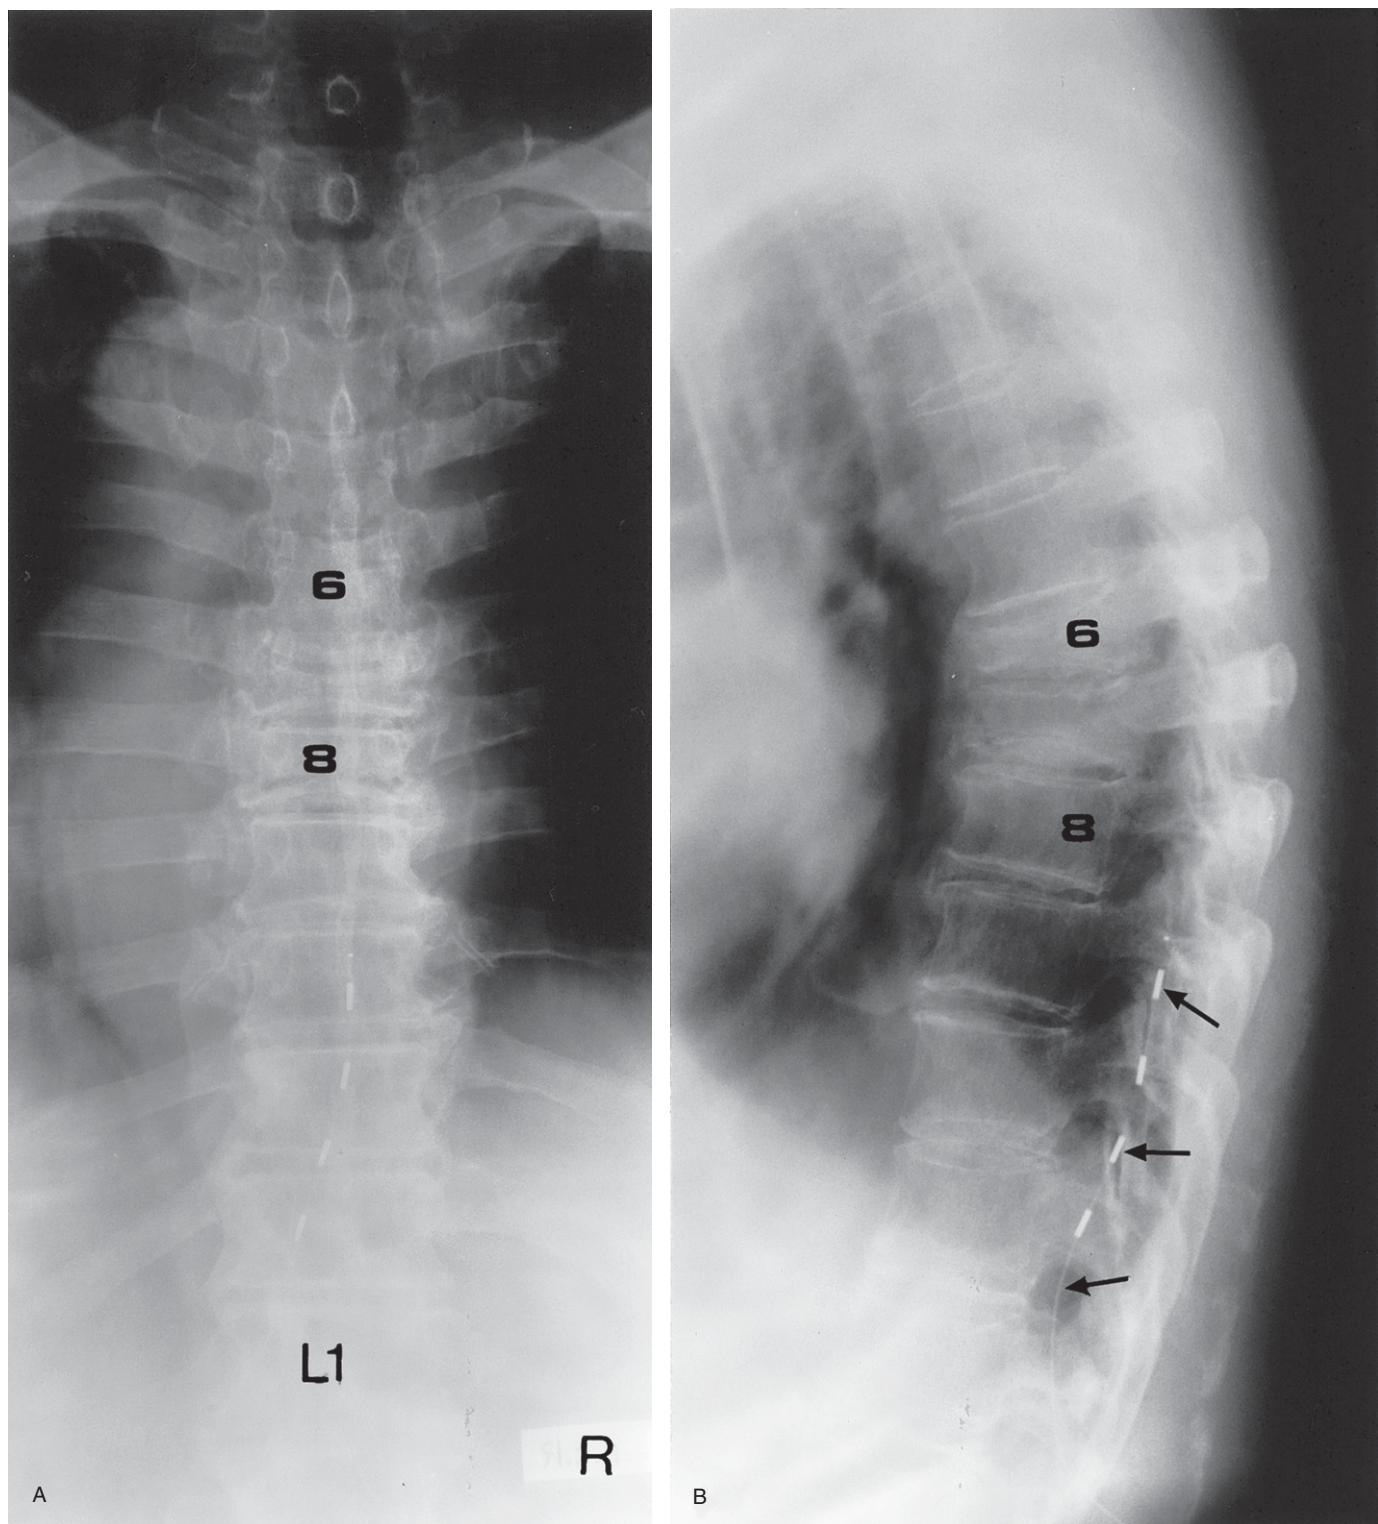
Plain film radiographs of the thoracic spine in (A) the anteroposterior and (B) lateral projections. Note the osteoporosis within associated significant vertebral body crush fractures at the T6 and T7 levels. Also note the gas in the T7–8 disc and the epidural spinal cord catheter terminating at the level of T9 (see arrows).
